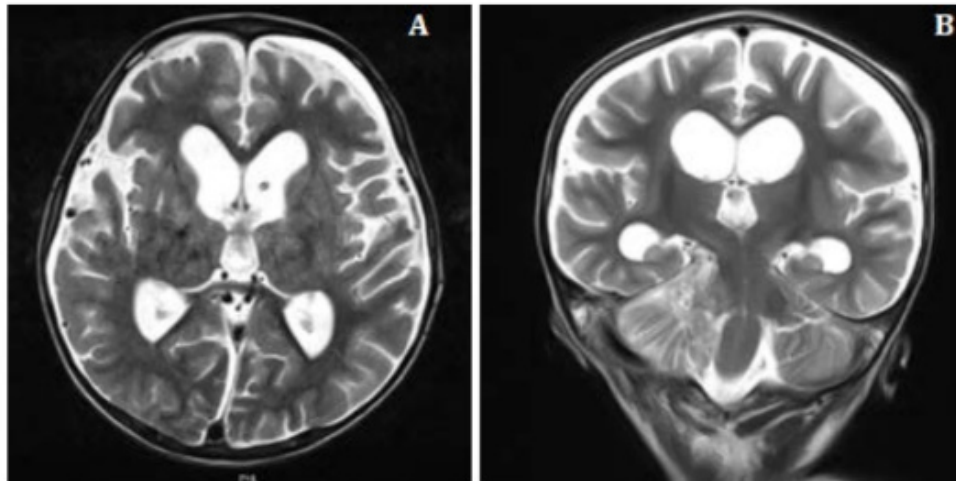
Postoperative contrast-enhanced brain MRI. Panel A shows the axial view and Panel B the coronal view, demonstrating postsurgical changes in the right posterior fossa and a residual extra-axial lesion with persistent mass effect and ventricular enlargement
